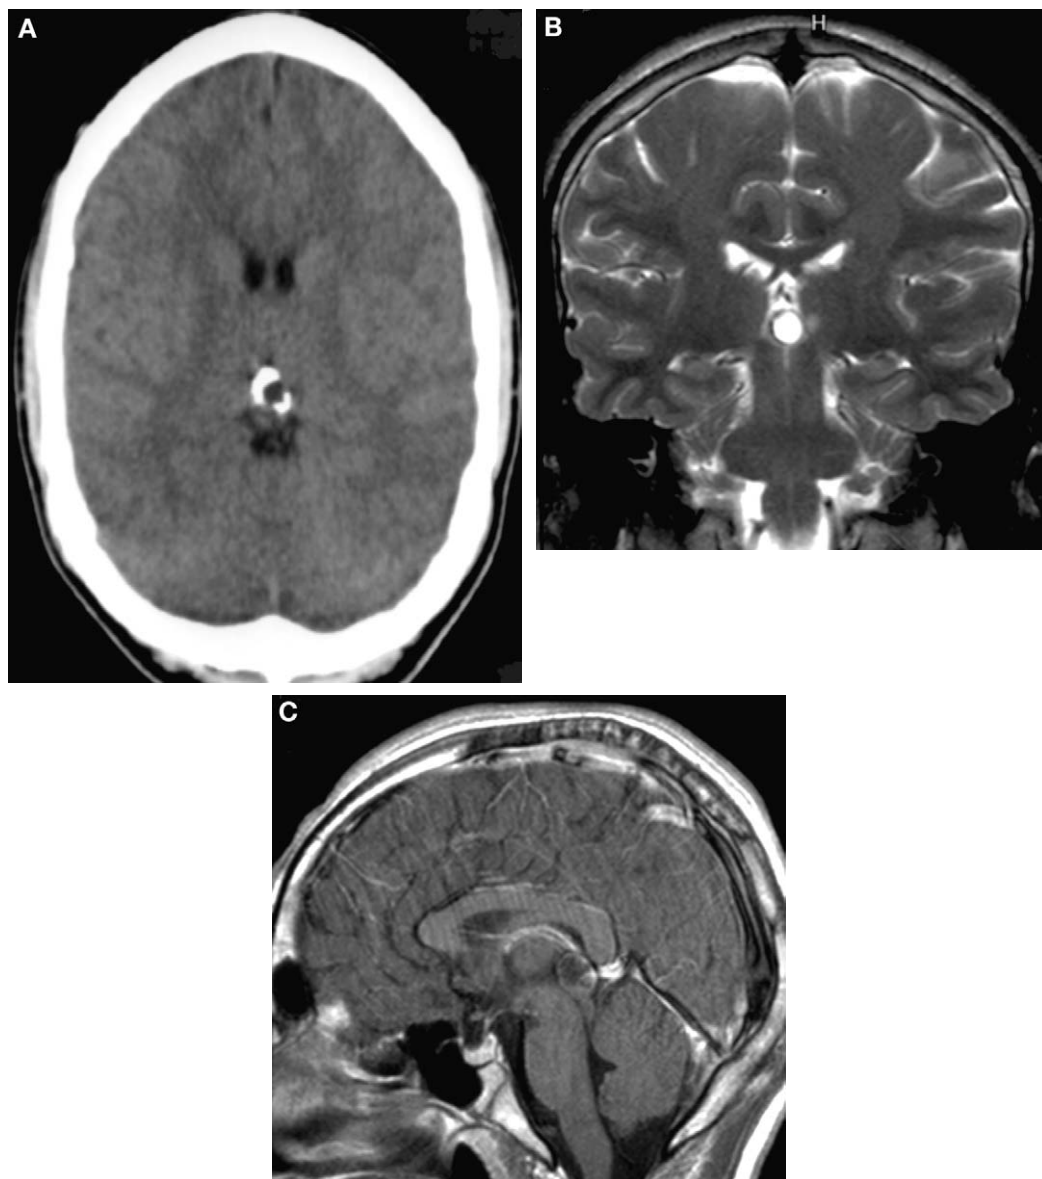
Pineal cyst. (A) Unenhanced CT scan shows a low-density lesion with thick rim calcifications in the region of the pineal gland. Coronal T2-weighted image (B) and sagittal T1-weighted postcontrast image (C) confirm the presence of a nonenhancing cyst within the pineal gland. Note normal appearance of the third ventricle and lack of calcification visualization on the MRI scan.
